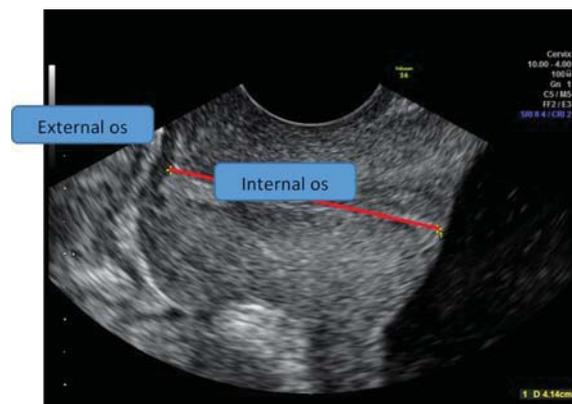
Ultrasound image of transvaginal cervical length in cases of T or V-shaped cervix.
